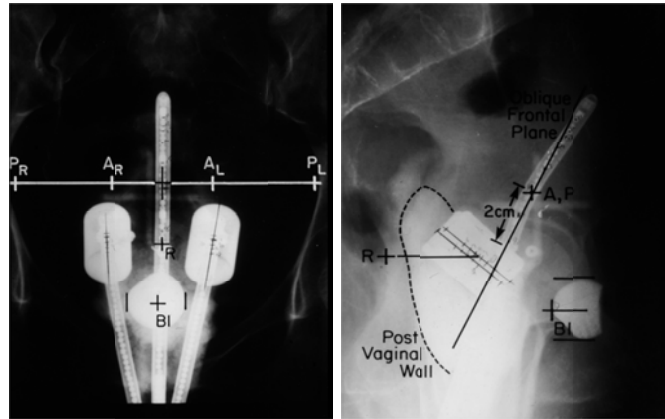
Orthogonal x-ray films of the ICB applicator (tandem and colpostats) patient (Courtesy of Dr. Jeffrey F Williamson).
